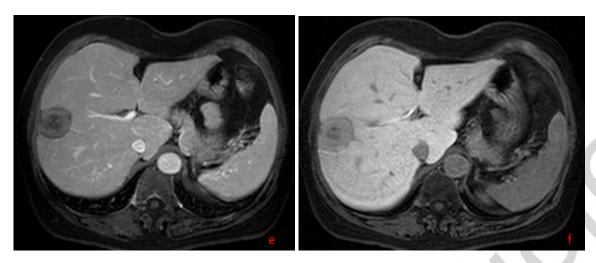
The tumor shows a six-layered heterogeneous signal intensity on DWI (a) and T2WI (b), and a three-layered target appearance on T1WI (c) with rim enhancement on the arterial and portal phase (d, e), and as a low signal target with a hypointense core on the hepatobiliary phase (f).
